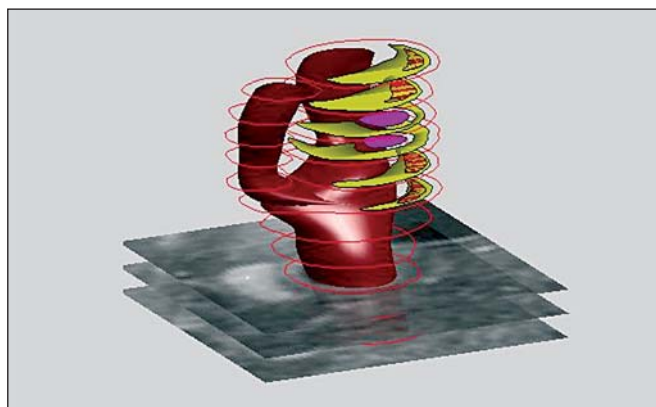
3D reconstruction of lumen and wall of a human carotid artery at ten-month follow-up based on MRI (pink: ulcer, yellow: lipid necrotic core, yellow/red: intraplaque haemorrhage).
